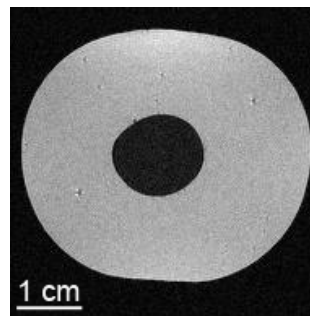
MRI cross section image of an Elastosil cylinder embedded into Permagel using a 2D spin echo sequence (FOV = $49 \times 49 \text{ mm}^2$, TH = 1 mm, 2 averages, TR = 1 s, TE = 8 ms).
